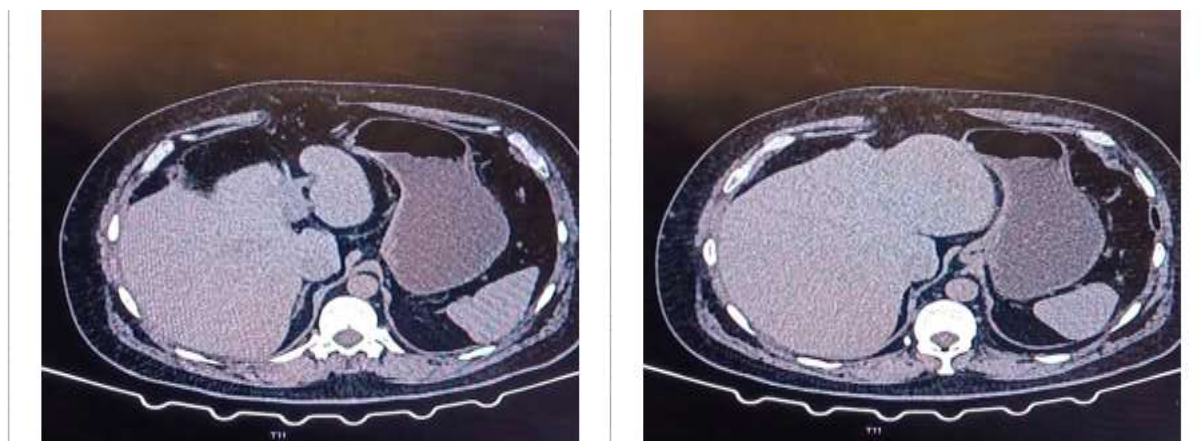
(A, B): Axial contrast-enhanced CT of the upper abdomen showing the subxiphoid (M1) fascial defect (A) and, at an adjacent level, herniation of preperitoneal fat through the defect (B).
